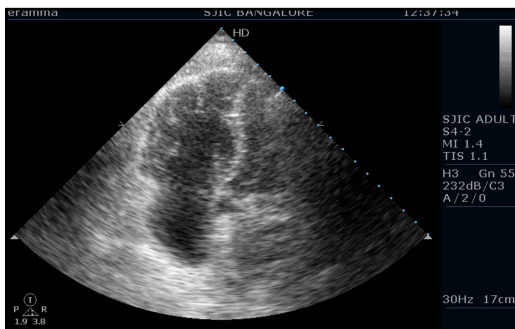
(A–C) Echocardiography revealed a dilated right atrium and ventricle, moderate tricuspid regurgitation and M-mode echocardiography revealed an akinetic mid-right ventricular free wall with a hyper contractile right ventricular apex (McConnell's sign).
